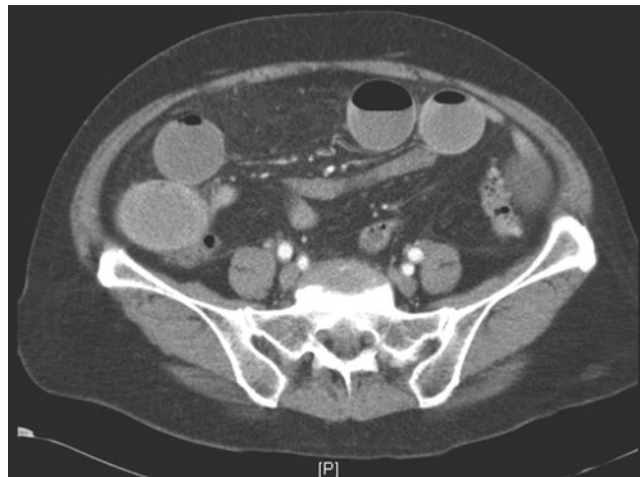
Small bowel obstruction. CT abdomen demonstrates dilated small bowel loops with air-fluid levels, collapsed distal small bowel, and collapsed colon
